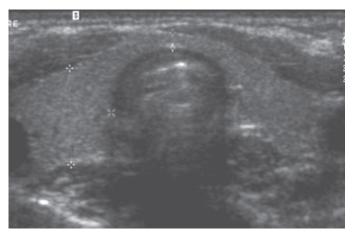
Thyroid ultrasound image of child B:4 with a normal thyroid, showing normal echogenicity and normal echotexture.
